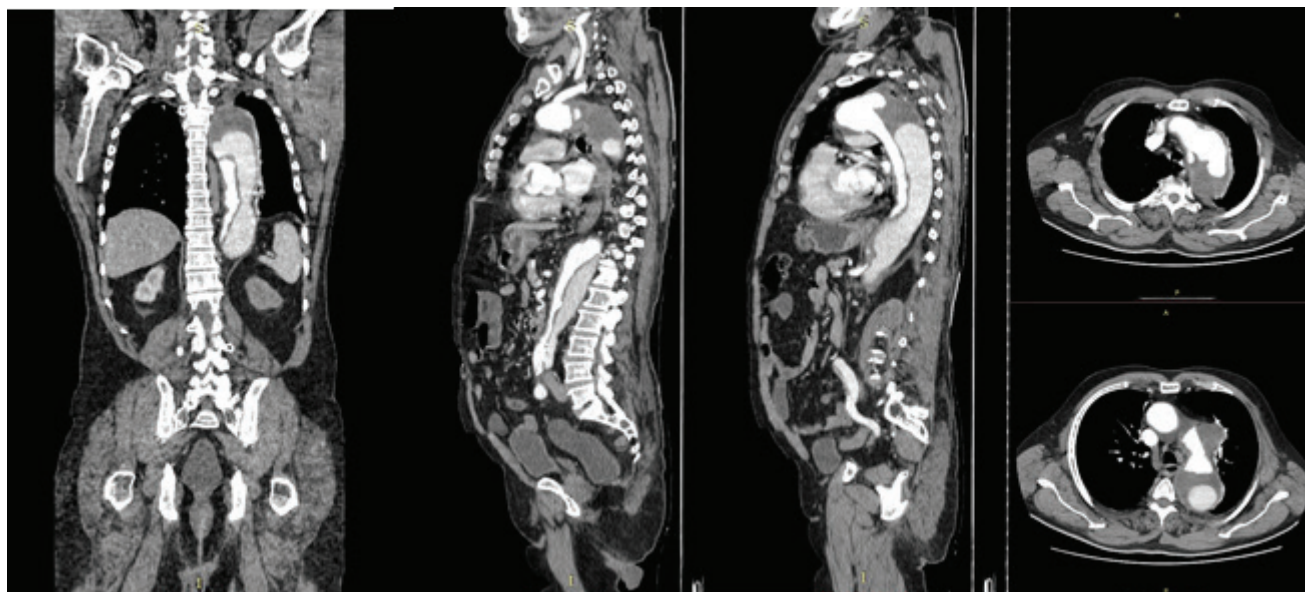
Contrast computed tomography images show the origin and extension of the dissection. The filling defect represents the large thrombus. Note the dilated proximal part of aorta which compresses the left recurrent laryngeal nerve.
